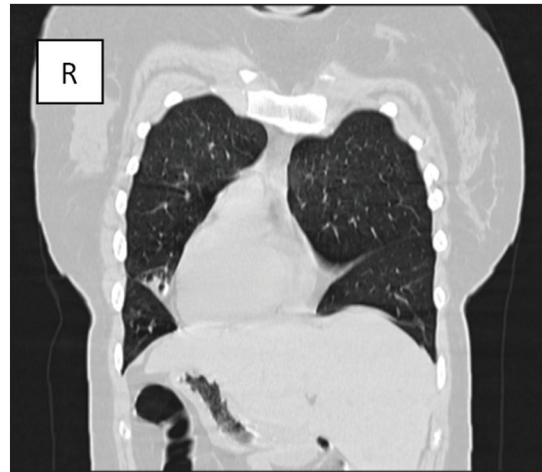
Coronal chest computed tomography scan images reveals cardiac apex toward the right side. Collapse of the lingular lobe is well seen. The liver soft-tissue density is noted on the left side with stomach and splenic flexure on the left side
